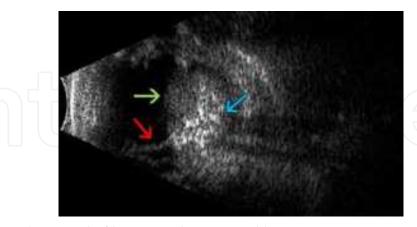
Ocular ultrasound of large exophytic retinoblastoma. Courtesy. www.retinaatlas.com
